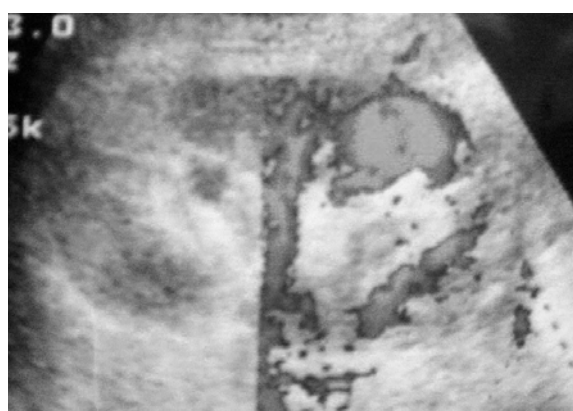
Color Doppler ultrasound shows a vortex circulation in the lower pole of the right kidney.
